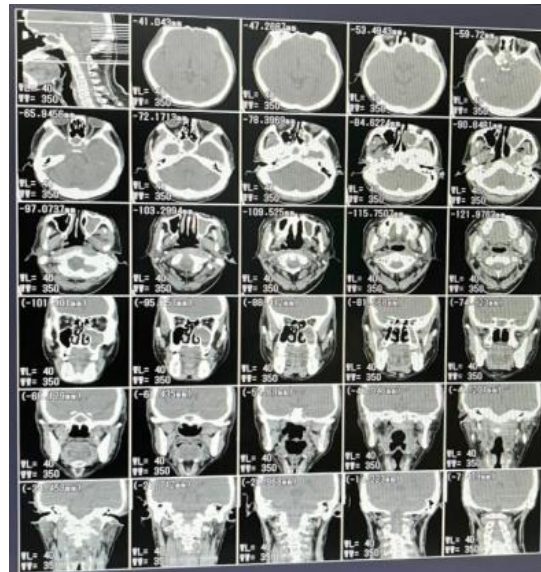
CT-Scan image results according to theory
